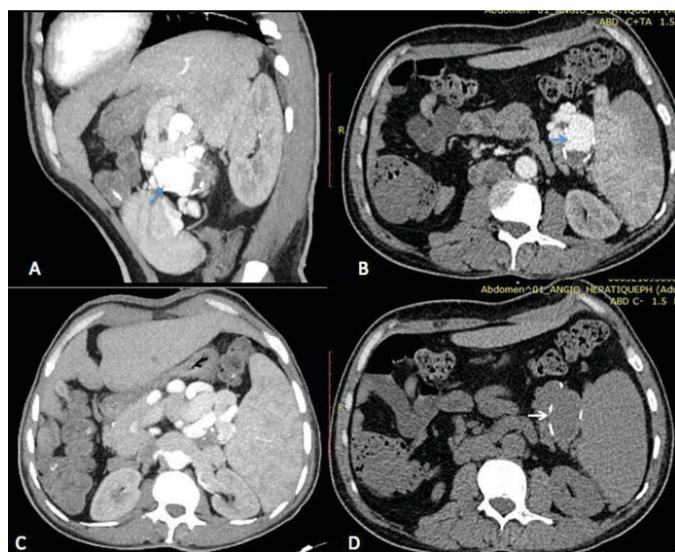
CTA images with maximum intensity projection (MIP) (A, C) showing a tortuous splenic artery with a partially thrombosed aneurysms (B) (blue arrow). Some calcification was noted in the walls of the aneurysm visible on CT scan images before intravenous contrast (white arrow) (D).
